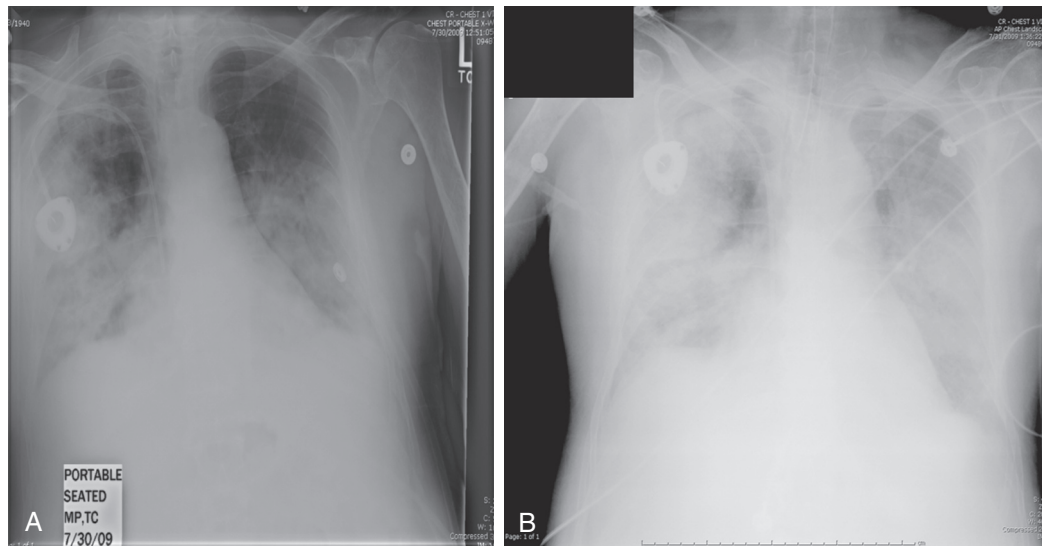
■ A, Chest radiograph of a 70-year-old male with B-cell lymphoma and hypogammaglobulinemia, with primary influenza pneumonia at the time of ICU admission. Note Port-a-Cath in right anterior chest wall and diffuse pulmonary infiltrates, most prominently seen in both lower lung fields. B, Chest radiograph of same patient 3 days later; note diffuse alveolar filling process associated with profound hypoxemia. The patient expired despite oseltamivir and ventilatory support, with severe hypotension and acute kidney injury.
